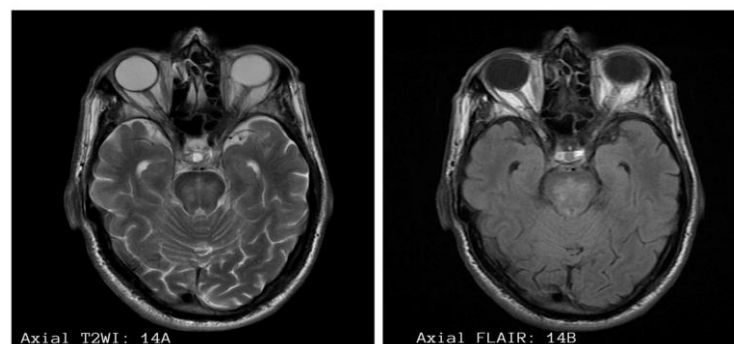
Images from a subject with osmotic demyelination syndrome showing hyperintense lesions in central pons on T2WI (14A) and FLAIR (14B).
